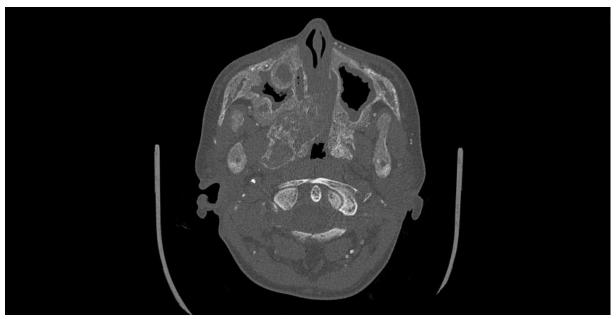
CT scan of head showing deformation of maxillary sinuses.
